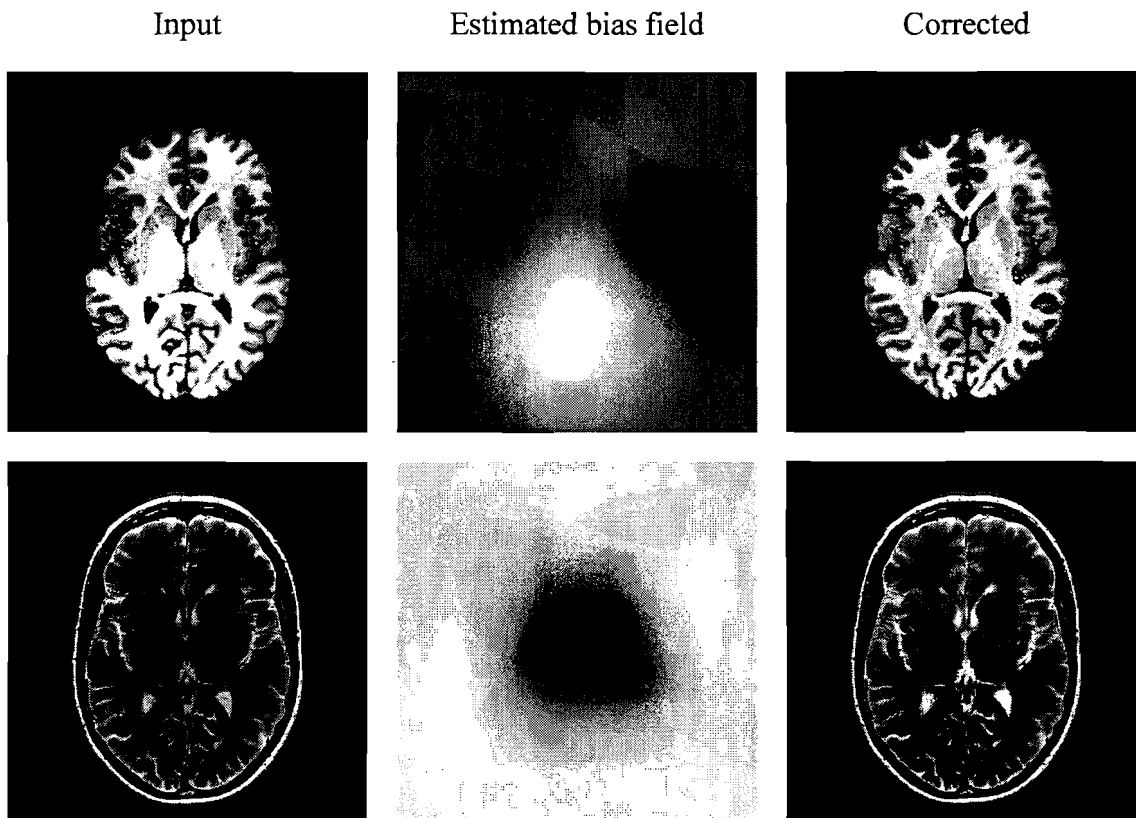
Results of implemented bias correction method on real data. On the left the input images, in the middle the estimated bias field, on the right the corrected images. Top row T1-weighted image, bottom row T2-weighted image.
